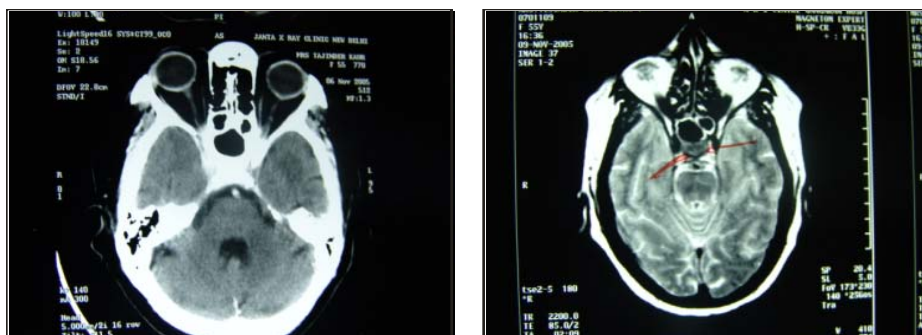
The CT scan and MRI scan of patient 1 demonstrating relatively clear orbits and ethmoidal sinuses but the presence of the fungal mass in the area adjacent to the cavernous sinus (thus producing the clinical signs suggestive of an orbital apex syndrome). This patient had rhino-orbital mucormycosis as proven after taking an endoscopic biopsy.
